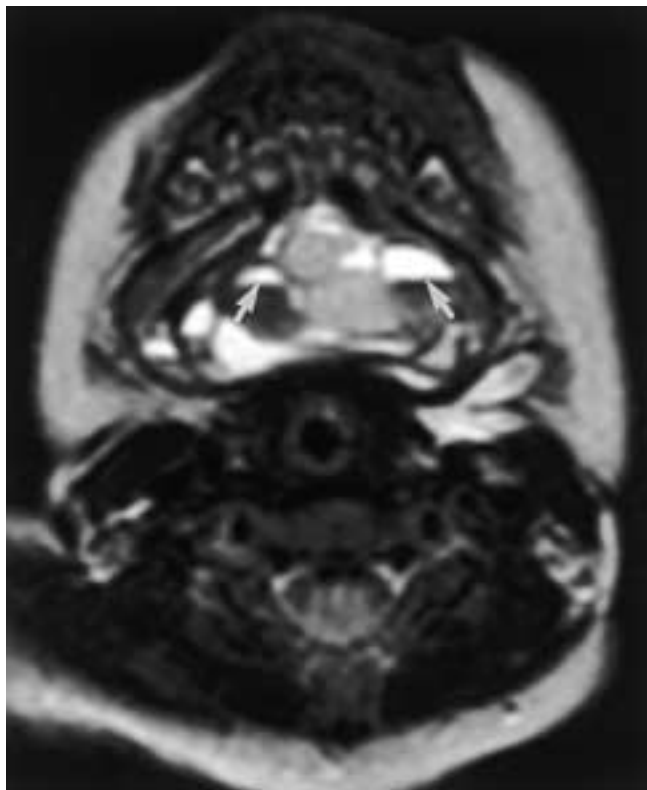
LM in a young boy. Axial FSE T2-weighted MR image demonstrates fluid-fluid levels (*arrows*) that are characteristic of LM.
